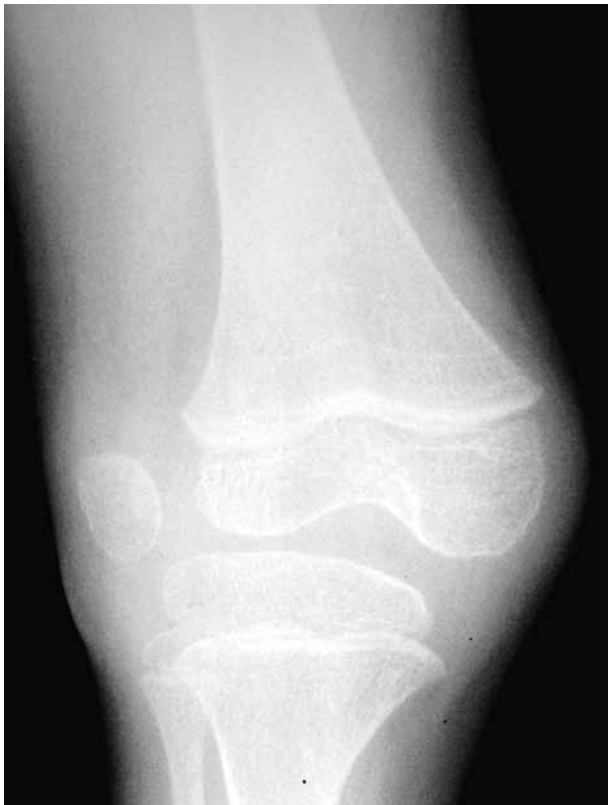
Radiograph of right knee of the patient with Down's syndrome confirming lateral dislocation of the patella.
